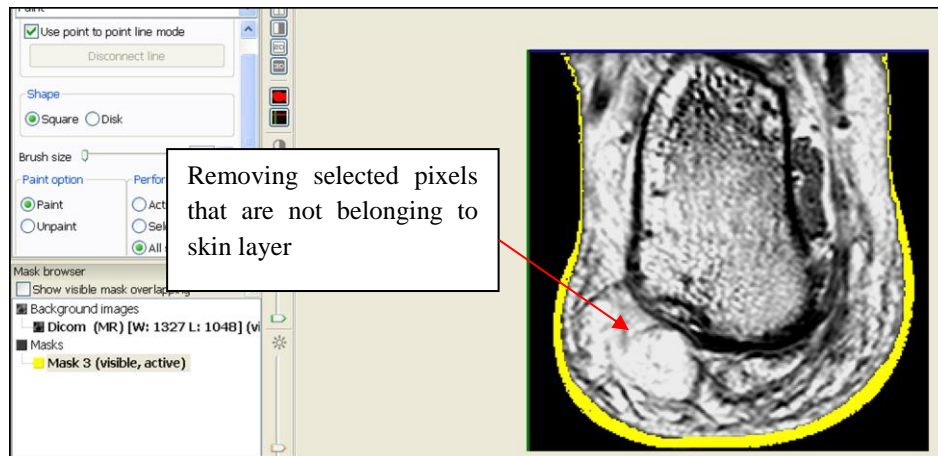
Manually refining MR images using the paint segmentation tool.
